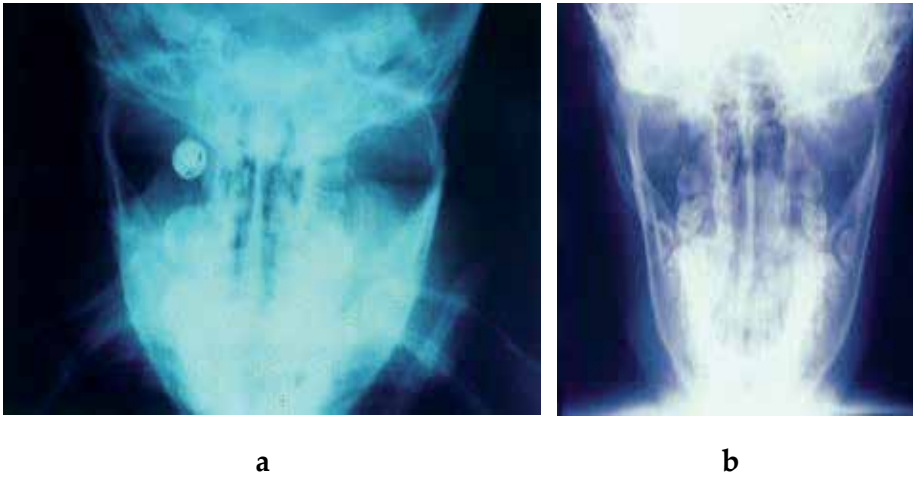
Same patient shown in Figure 7. a) Note the presence of condylar neck fracture at posteroanterior projection radiograph immediately before treatment with removable appliance. b) Follow-up radiograph of the patient which reveals adequate alignment of the fractured bony segment after 1-year.
